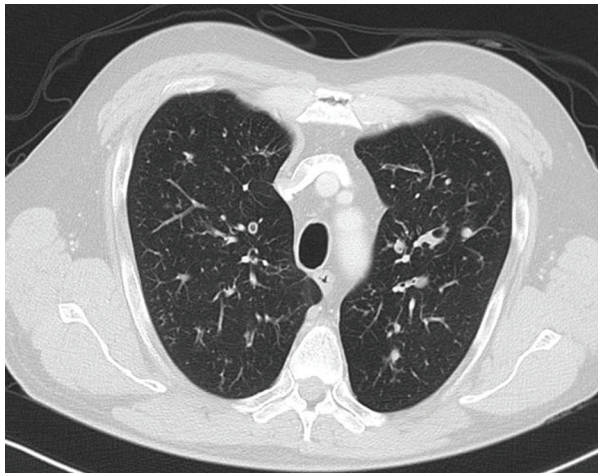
Computed tomography scan of an asthmatic patient with allergic bronchopulmonary aspergillosis (ABPA) showing central bronchiectasis, mucus plugging, bronchial wall thickening and tree-in-bud appearance.
